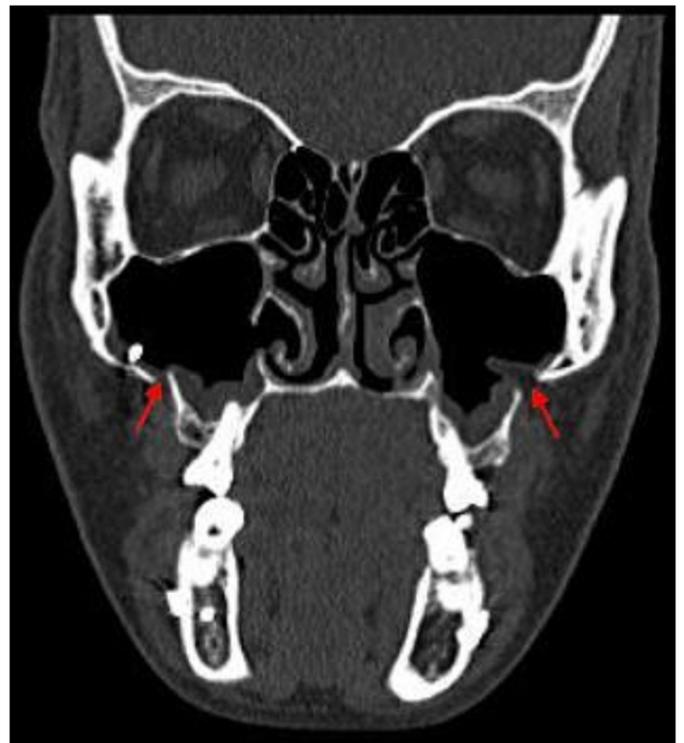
Postoperative coronal CT image showing persistent bony dehiscence at the base of the maxillary sinus (arrows) with evidence of mucosal thickening in the bilateral maxillary sinus.
